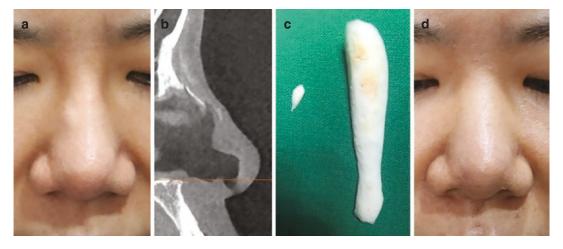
Palpable mass was shown in lateral wall. (a) Preoperative view, (b) preoperative CT scan, (c) removed silicone implant and fragment, and (d) postoperative view
